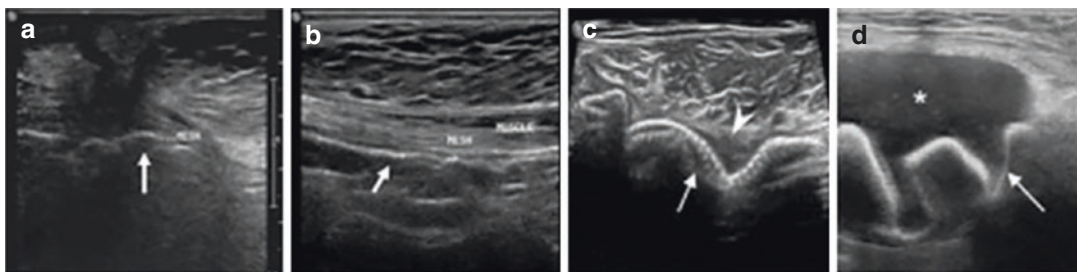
Mesh appearances on ultrasound using high-resolution linear probe. Wavy echogenic appearance of mesh (arrow) in a post umbilical hernia repair (a). Inlay placement of mesh appearing echogenic on ultrasound (arrow) (b). Early postoperative ultrasound shows wavy echogenic mesh (arrow) made prominent by surrounding thin seroma (arrowhead) (c). Mesh migration (arrow) into a collection (*) in a post-inguinal hernia repair (d)
